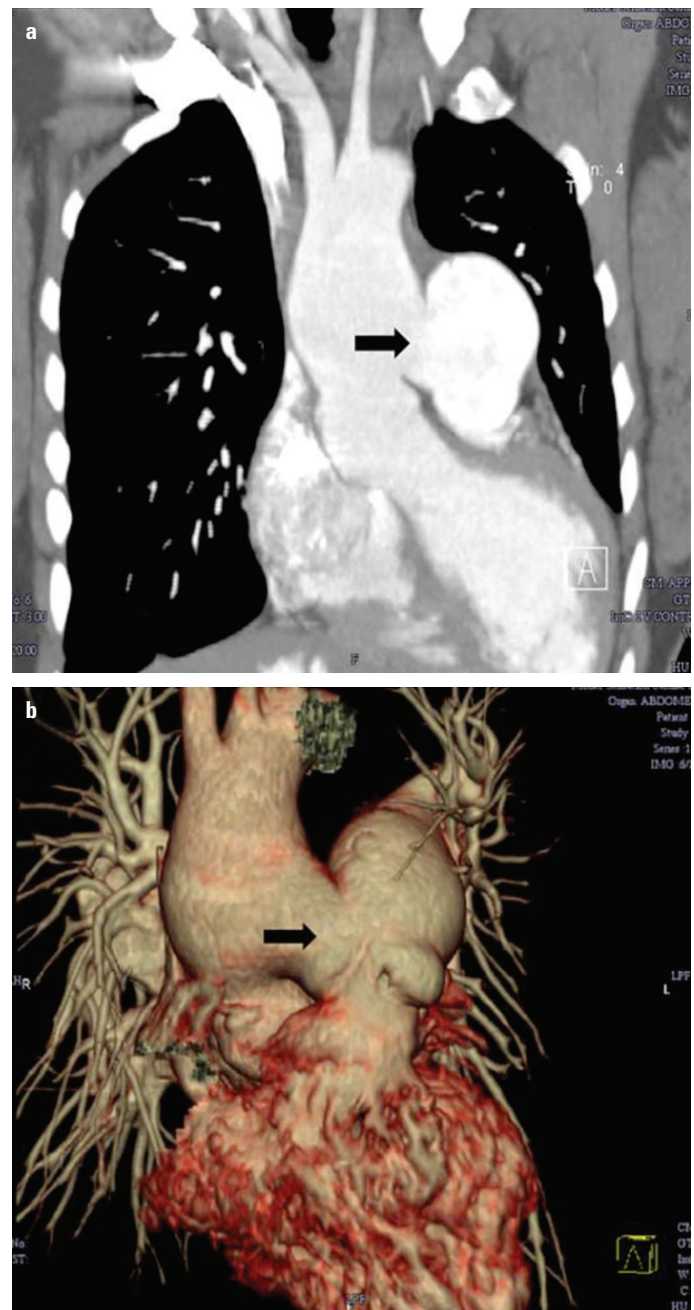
(a) Multi-detector computed tomography (MDCT) image of the chest with contrast showing a large aortopulmonary window (APW) (arrow mark). (b) Reconstructed MDCT images showing a large APW (arrow mark)
